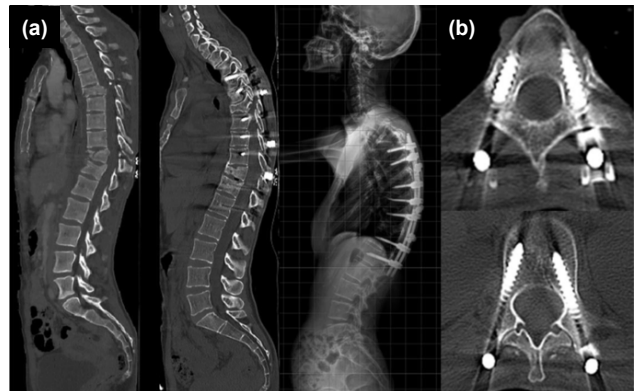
(a) Preoperative sagittal computed tomography (CT) scan, postoperative sagittal CT imaging, and sagittal X-ray image of the patient who underwent surgery for non-continuous fracture. (b) Postoperative axial CT scan of the screws at thoracic 5 and lumbar 1 levels of the same patient, respectively.
